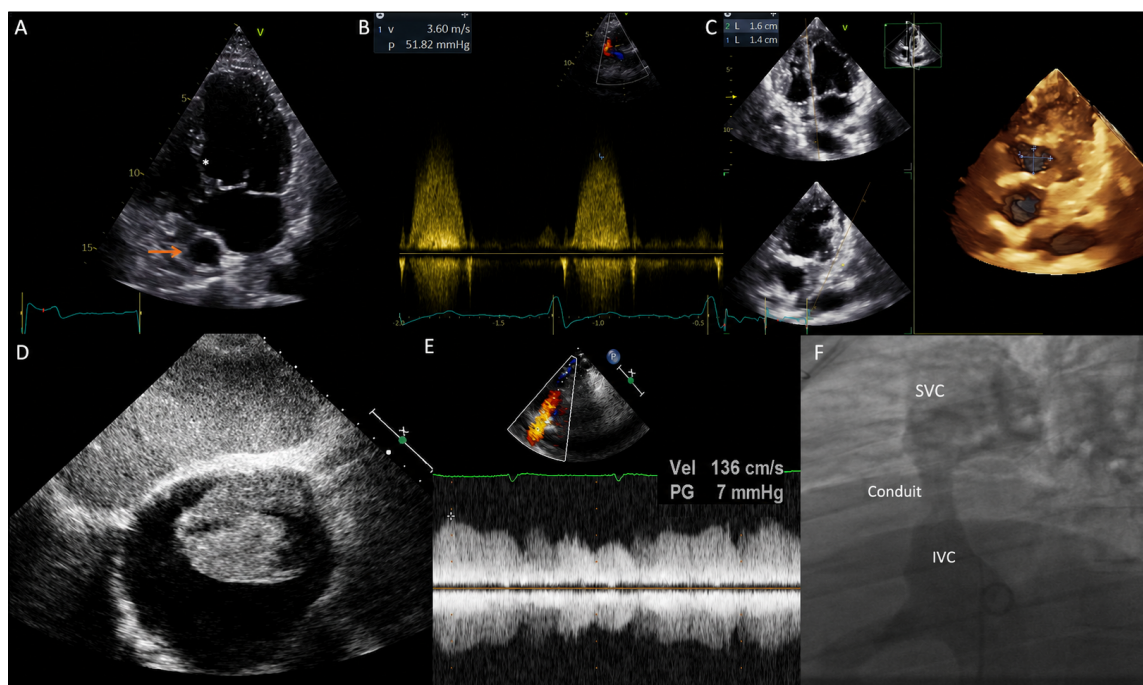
Possible Fontan features on imaging. (A) Transthoracic echocardiographic apical 4-chamber view in a patient with double inlet left ventricle and rudimentary right ventricle. The asterisk indicates the bulboventricular foramen, while the arrow points to the extracardiac Fontan conduit. (B) Continuous Doppler signal of a restrictive bulboventricular foramen in a patient with tricuspid atresia and transposed great vessels resulting in significant subaortic obstruction. (C) Bulboventricular foramen size assessed with 3-dimensional echocardiography and en face visualization with multiplanar reconstruction. (D) Subcostal echocardiographic view showing a bulky thrombus inside the grossly dilated right atrium in a patient with direct atriopulmonary connection. (E) Suprasternal view with pulsed Doppler interrogation revealing increased flow velocity at distal conduit anastomosis with reduced respiratory variations, suggestive of Fontan conduit obstruction. (F) Venous angiography during cardiac catheterization in the same patient as E confirming a discrete stenosis of the conduit, which was successfully treated with conduit stenting. SVC: superior vena cava; IVC: inferior vena cava
